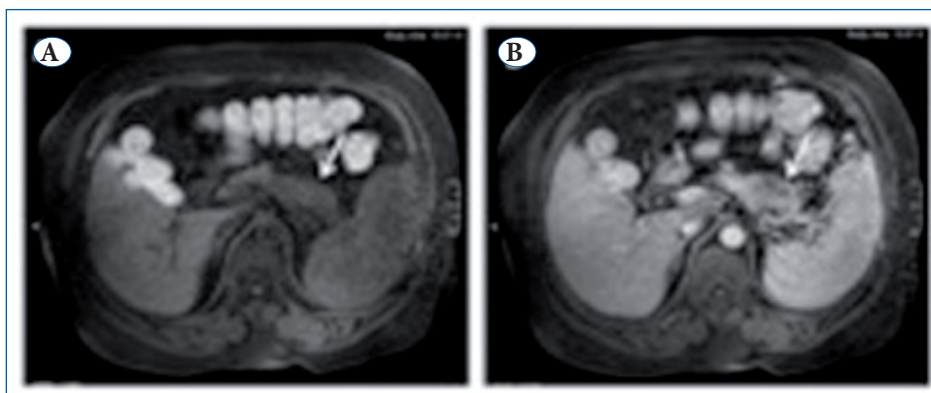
A) Precontrast fat saturated T1 weighted MR image shows the expansion in pancreatic tail with ill defined borders (arrow). B) Contrast- enhanced fat saturated T1 weighted MR image in portal phase shows the hypointense expansile mass with ill defined borders in the tail of pancreas (arrow).
